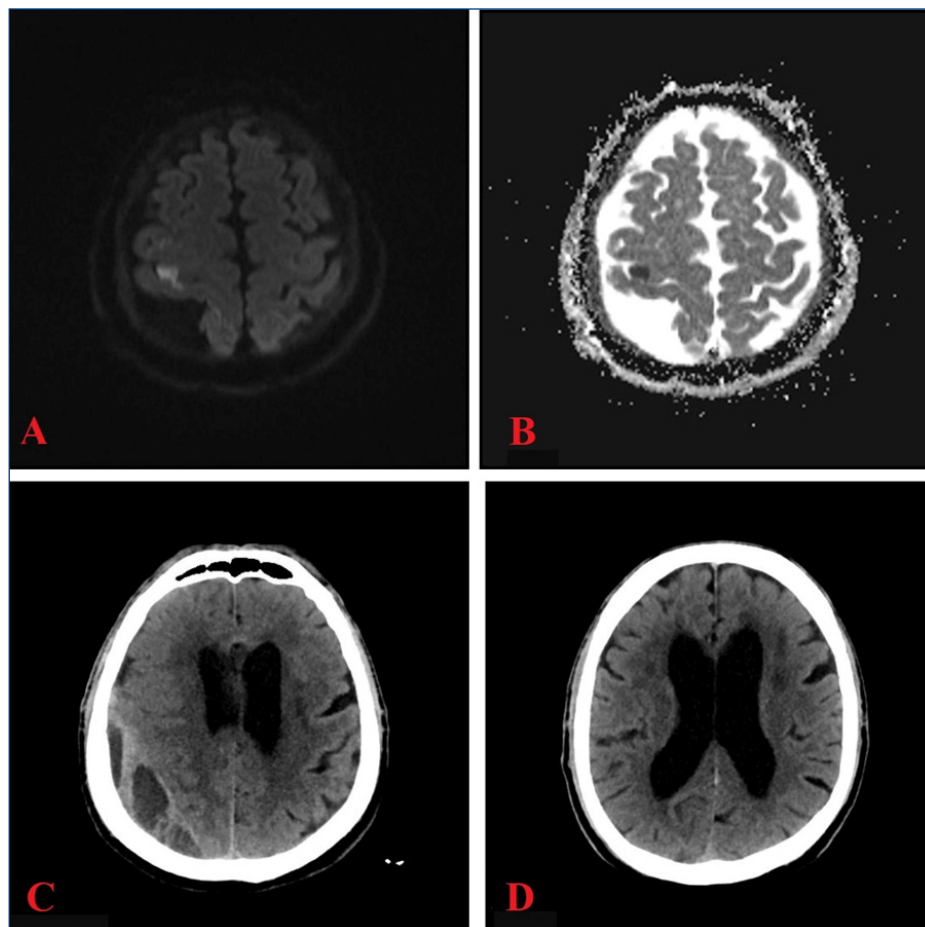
The patient's DWI MRI imaging shows hyperintense areas. In Figure 1B, the corresponding ADC MRI reveals hypointense regions indicative of an acute stroke, along with an appearance compatible with subdural effusion on the same side. Figure 1C – On the cranial CT taken during the patient's one-year follow-up, it is observed that the right-sided subdural effusion has transformed into a subdural hematoma, causing cortical compression. Figure 1D – In the follow-up CT taken 12 months after the patient's surgery for CSH, the brain parenchyma appears expanded, the midline is properly aligned, and the sulci appear relaxed.
